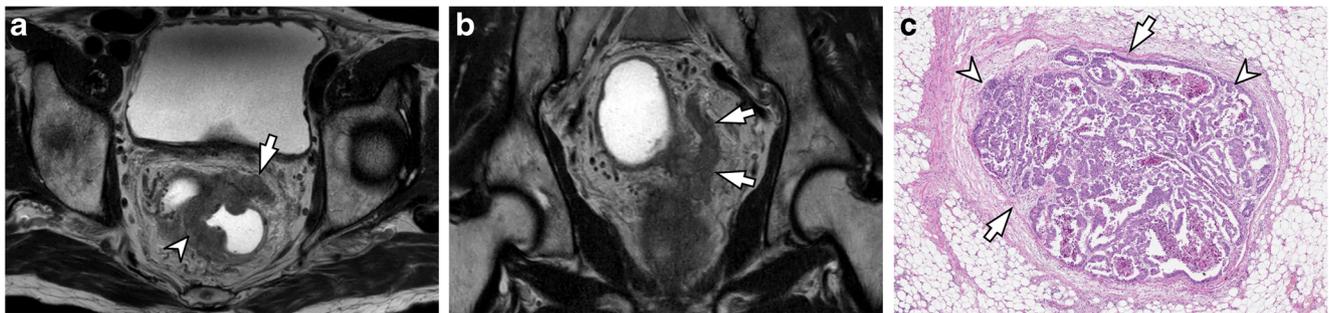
An 87-year-old man with rectal cancer. a, b On axial (a) and coronal (b) T2-weighted MR images, a serpiginous extension of the tumor signal (arrows) is noted around the tumor (arrowhead). This patient was graded as 4 (definitely present) for mrEMVI by all three radiologists and subsequently underwent Hartmann's operation without
